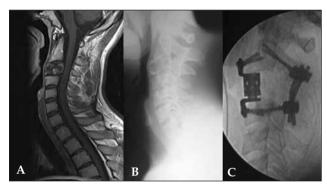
Imaging findings in Case 1. Preoperative sagittal MRI (A) and lateral radiograph (B) of the cervical spine confirming a tumor predominantly affecting the C3 vertebral body. (C) Intraoperative fluoroscopy of the final construct. The construct consisted of the anterior distractable interbody cage with plate. Posteriorly the C2-C4 pedicle screw fixation with rods can be seen.
